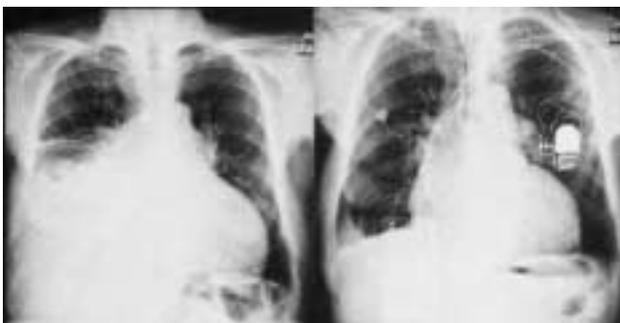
On the left: chest X-ray before implant shows cardiac enlargement, vascular redistribution, bilateral alveolar edema and right pleural effusion. On the right: at pre-discharge chest X-ray, a marked reduction in both cardiac size and pulmonary vascular congestion is present compared with baseline.
